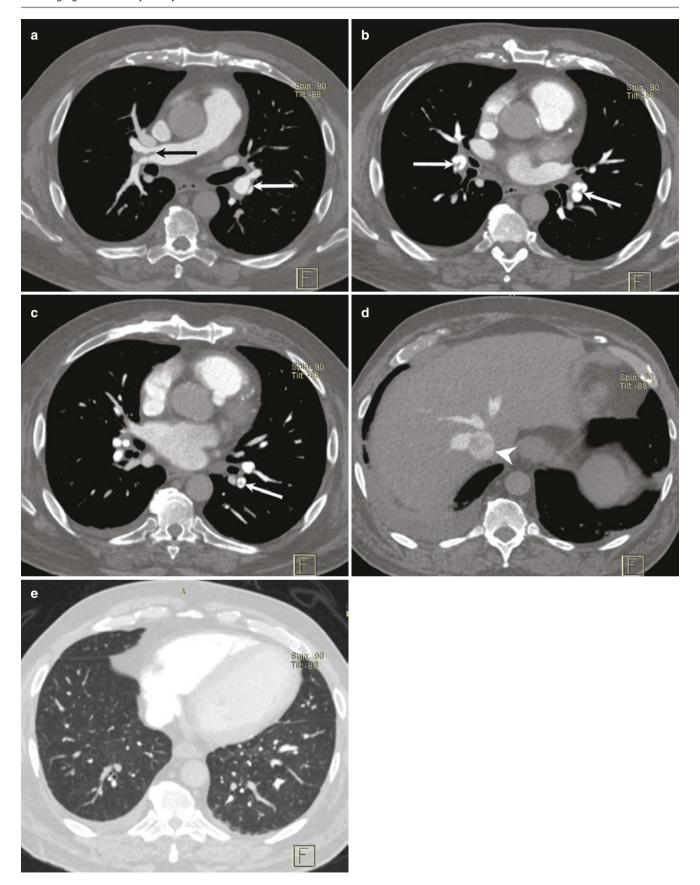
A 59-year-old man with PAH from pulmonary thromboembolism. $(\mathbf{a}-\mathbf{c})$ Axial CTPA images show linear bands or "webs" in bilateral pulmonary arteries (arrows). (d) Axial CT image caudally shows
